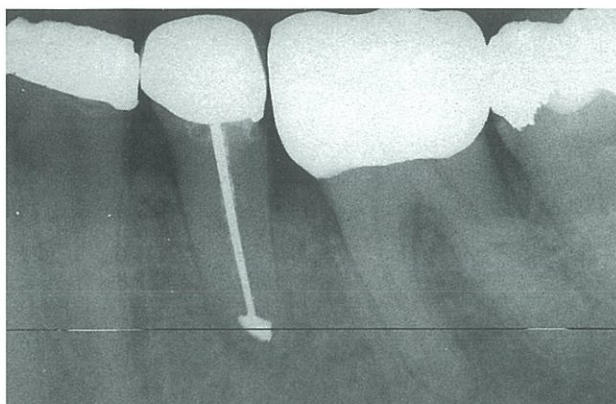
Case 3, 5-year follow-up radiograph. Reformed lamina dura is noted both at the interproximal marginal crest between teeth nos. 20 and 21 and at the apex of tooth no. 20.
